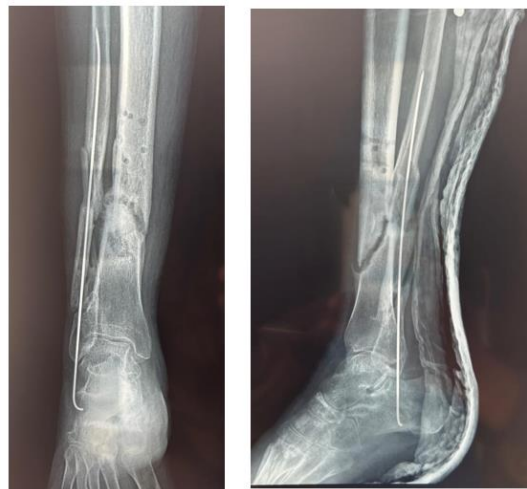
Anteroposterior and lateral radiographs demonstrating atrophic aseptic tibial nonunion with consolidated fibula, prior to surgical intervention (Case 2)
